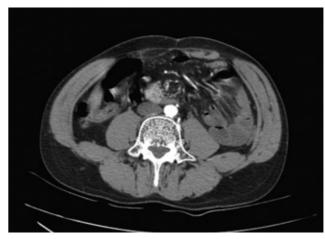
Axial CT of abdomen with contrast – Mesenteric blood vessels burst to the right and front of a stagnant small intestine.
